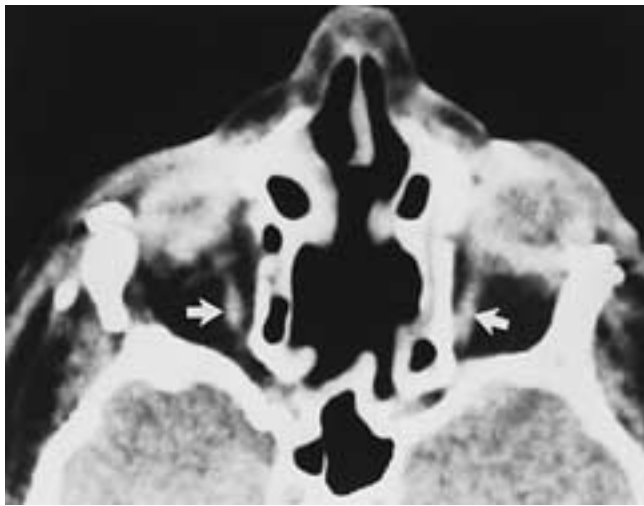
Crouzon's syndrome. CT scan shows the small inferior rectus muscles (*arrows*). Note the hypertelorism and postsurgical changes of the lateral orbital walls.
